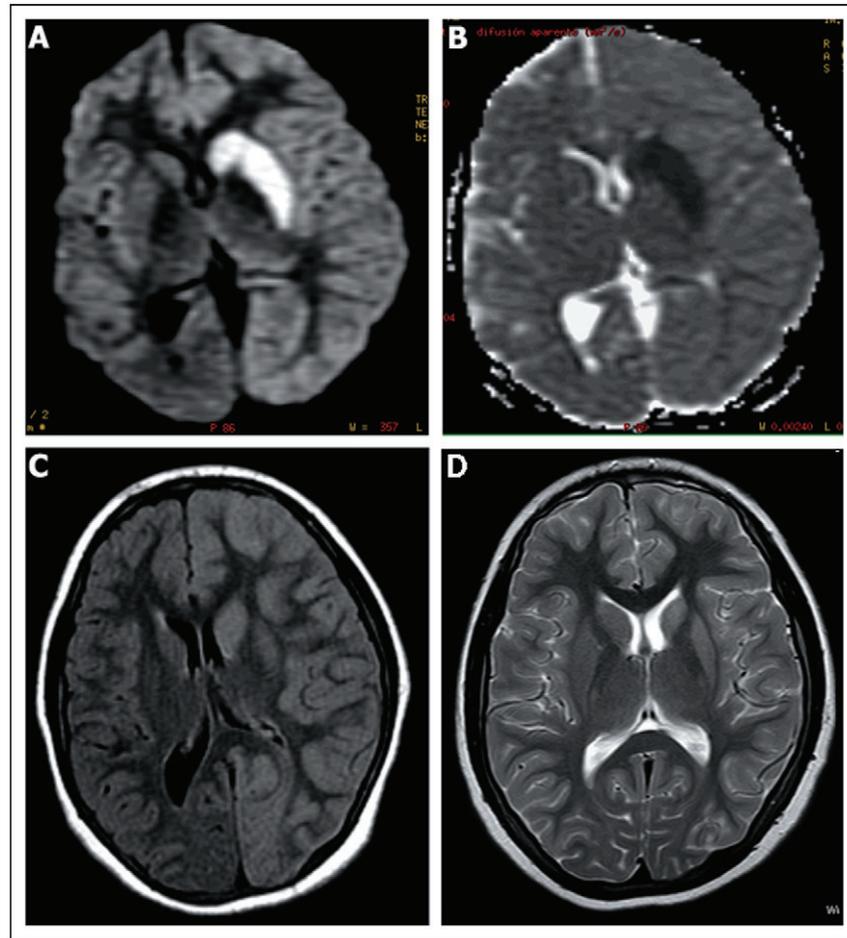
Neostriatal involvement in hemiplegic migraine. On day 2 of the attack, DW-MRI showing restricted water mobility (A) and corresponding low signal on apparent diffusion coefficient (ADC) map (B) in the left striatum, plus ipsilateral gyral hyperintensity on FLAIR-T2 sequence (C). T2-weighted image 2 years later, showing left neostriatal atrophy (D).
